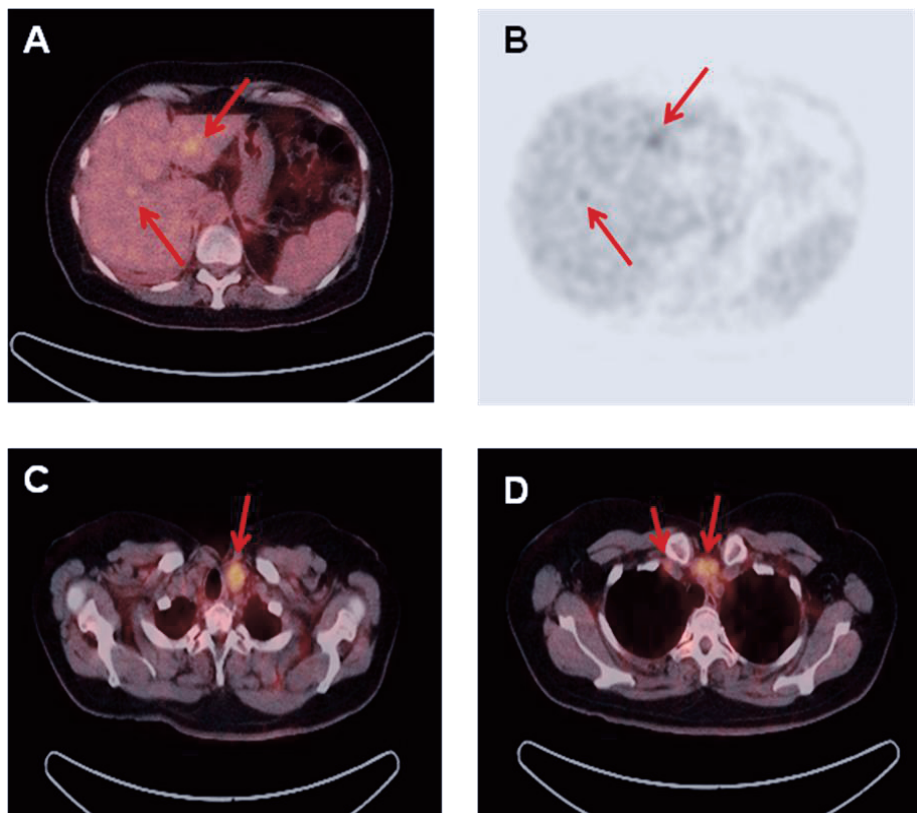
Sixty-three year old female with recurrent aggressive medullary thyroid cancer. FDG PET/CT was performed for restaging. A: Transaxial FDG PET/CT upper abdomen. B: PET, same transaxial slice as in A. C: Transaxial FDG PET/CT lower neck. D: Transaxial FDG PET/CT upper chest. PET shows increased FDG-uptake in metastatic lesions in the neck (C and D), subpleural / parasternal right side (D), in two lesions in the liver (A and B), and in the lungs (not displayed). Calcitonin is low, 34 pmol/L, however CEA=38 μ g/L. As demonstrated in this figure, poorly differentiated MTC may be associated with moderate or low calcitonin levels despite large tumor mass and progressive disease.
